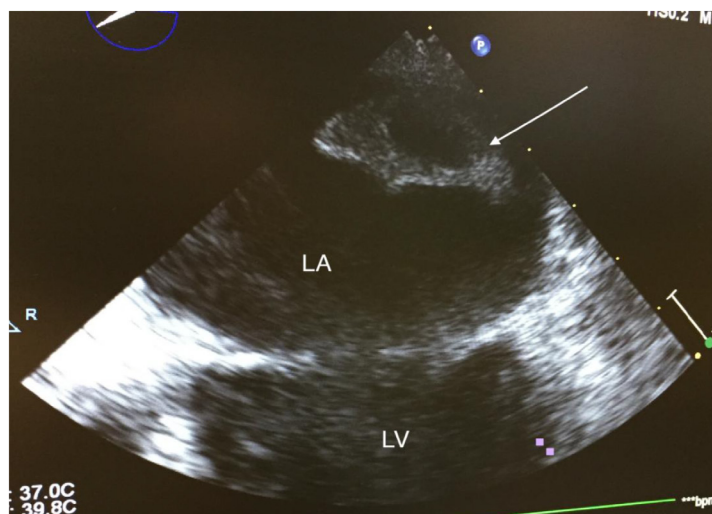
Two-dimensional transesophageal echocardiogram (TEE) after deployment of AtriClip, showing the largest thrombus in the left atrium (LA) indicated by the arrow.
